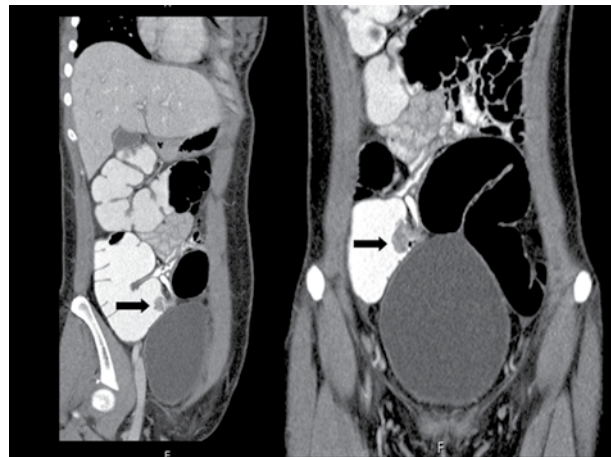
CT scan of the abdomen showed a large appendiceal proliferative mass (black arrow) protruding into the cecum.
